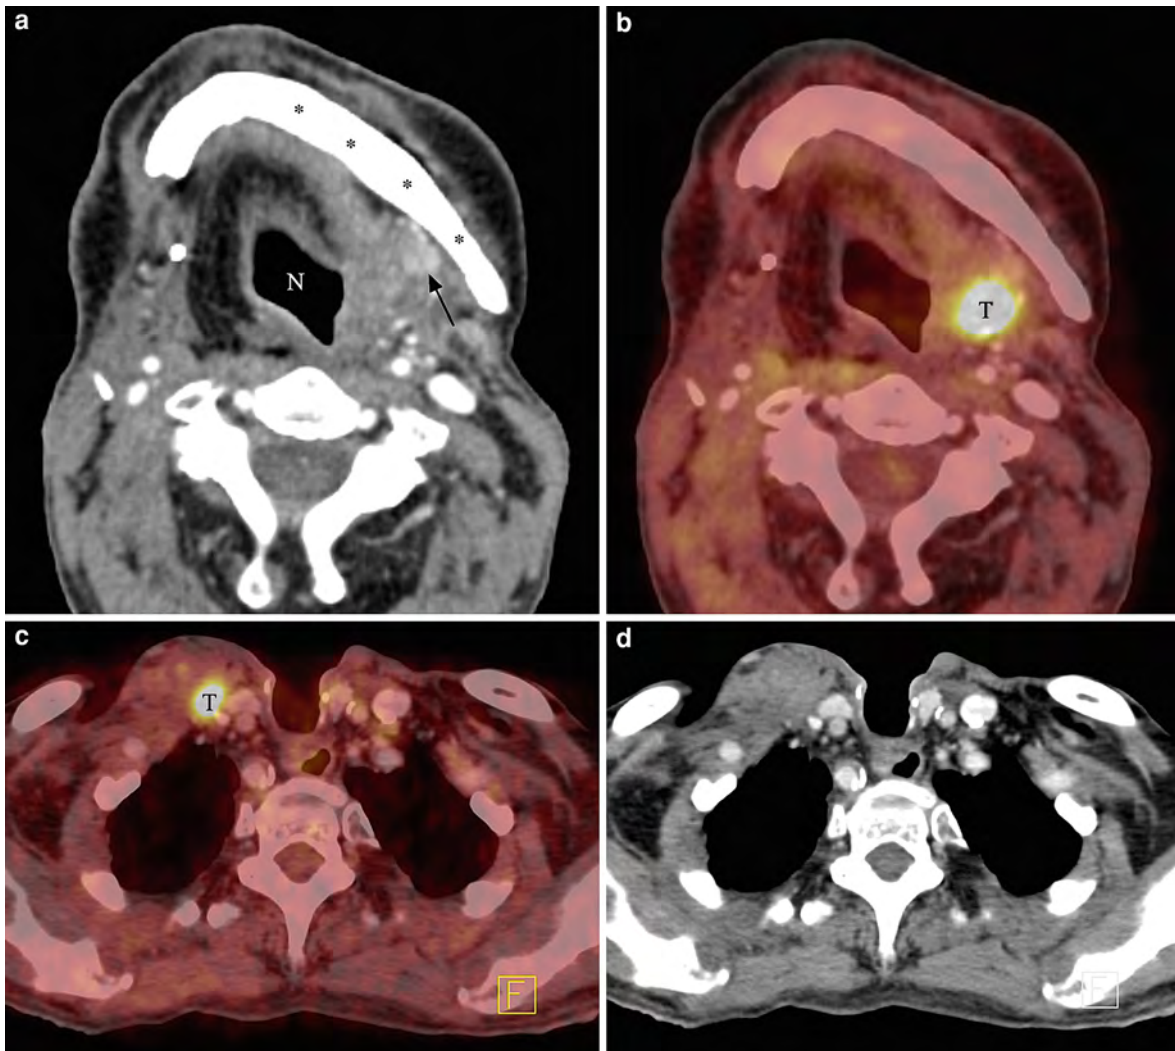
Fifty-seven-year old patient status post resection of advanced squamous cell carcinoma of the tongue base, pectoralis flap reconstruction and right lymph node dissection presents for follow-up surveillance. The contrast-enhanced CT image at the level of the mandible (a) shows asymmetric fat planes lateral to the neopharynx (*N* in a) with a small enhancing lesion (*arrow* in a) along the residual mandible (* in a) on the *left side*. The fused FDG-PET/CT image (b) reveals that the recurrent tumor (*T* in b) is actually more
